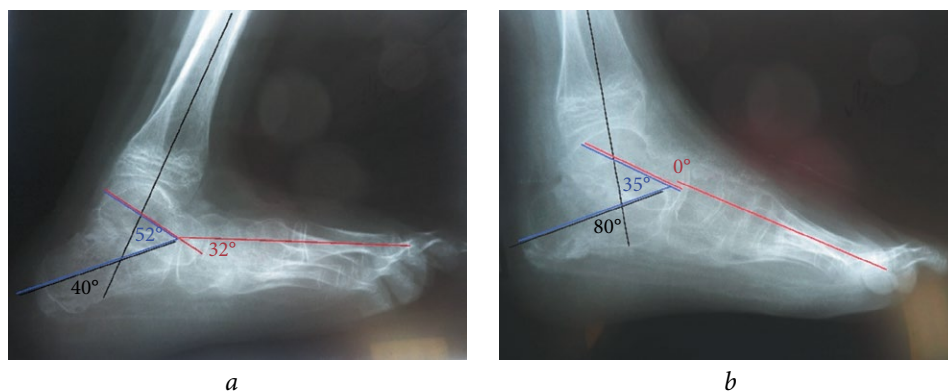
Patient L., 11 years old, with a diagnosis is neurogenic calcaneal deformity of the left foot: *a* — radiograph of the left foot in lateral projection upon admission: calcaneotibial angle is 40°, Meary's angle is 32°, sagittal astragalocalcaneal angle is 52°; *b* — radiograph of the left foot in lateral projection after the surgical treatment: calcaneotibial angle is 80°, Meary's angle is 0°, sagittal astragalocalcaneal angle is 35°
